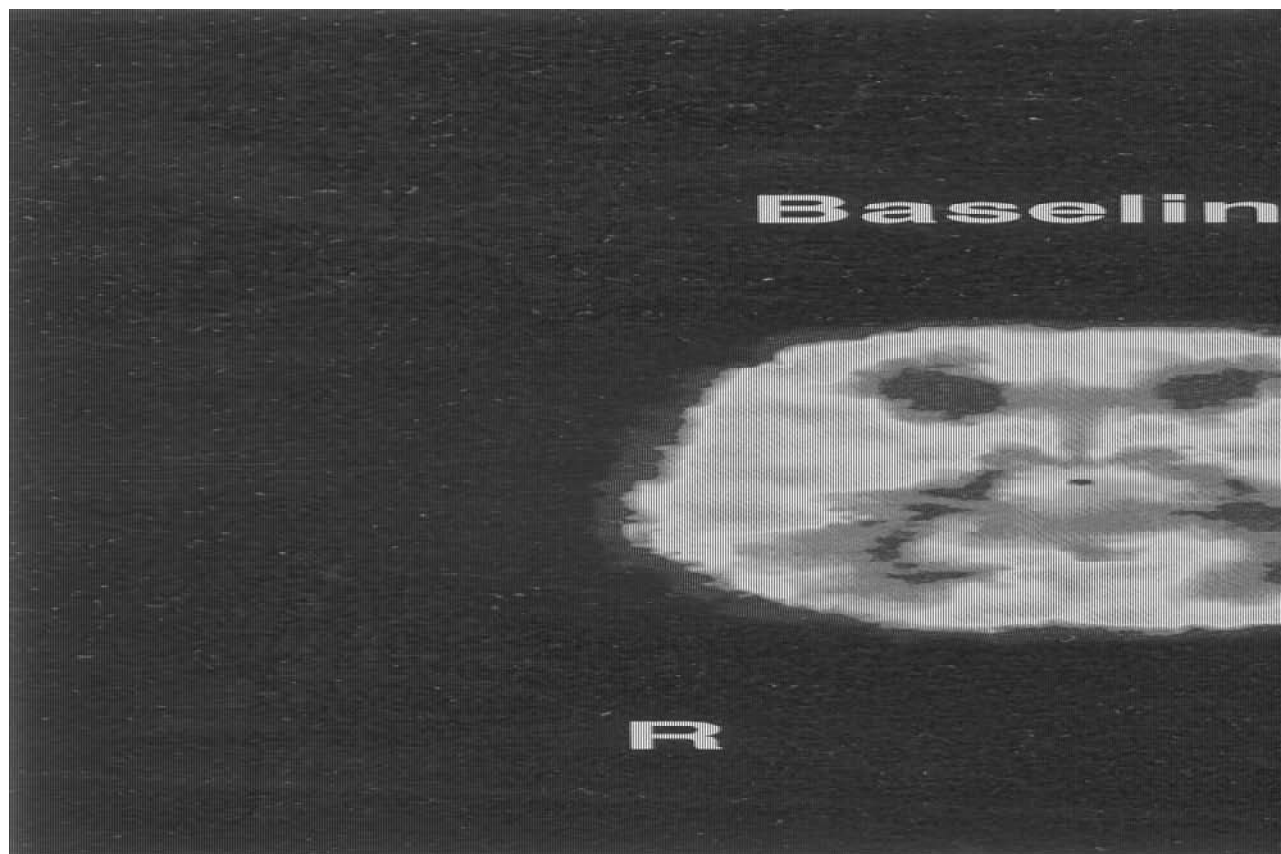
[^{18}F]FDG-PET images at the level of the basal ganglia from the same subject under baseline, (S)- and (R)-ketamine conditions. (S)-Ketamine and (R)-ketamine had opposite effects on absolute CMRglu (CMRglu: $\mu\text{mol}/100 \text{ mg}/\text{min}$), while (S)-ketamine increased global CMRglu, (R)-ketamine tended to decrease CMRglu in corresponding brain regions. (S)-Ketamine stimulated CMRglu markedly in the frontal and parietal cortex, while the occipital cortex was only moderately affected (hyperfrontality). The thalamus was the only subcortical region that showed a trend level increase in CMRglu. (R)-Ketamine decreased CMRglu significantly in the temporomedial cortex and left insula.
